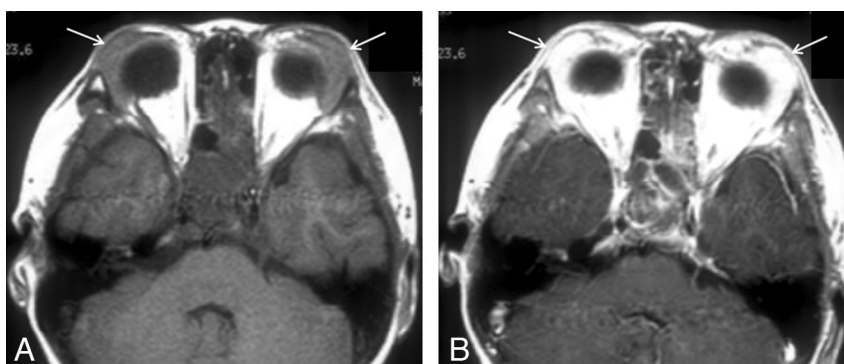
KD involving bilateral lacrimal glands in a 13-year-old boy. *A*, Axial T1-weighted MR image shows diffuse enlargement of bilateral lacrimal glands (arrows). The signal intensity of the lesions is slightly hyperintense to the adjacent muscle. *B*, Postcontrast axial T1-weighted MR image shows homogeneous marked enhancement of the lesions (arrows).
